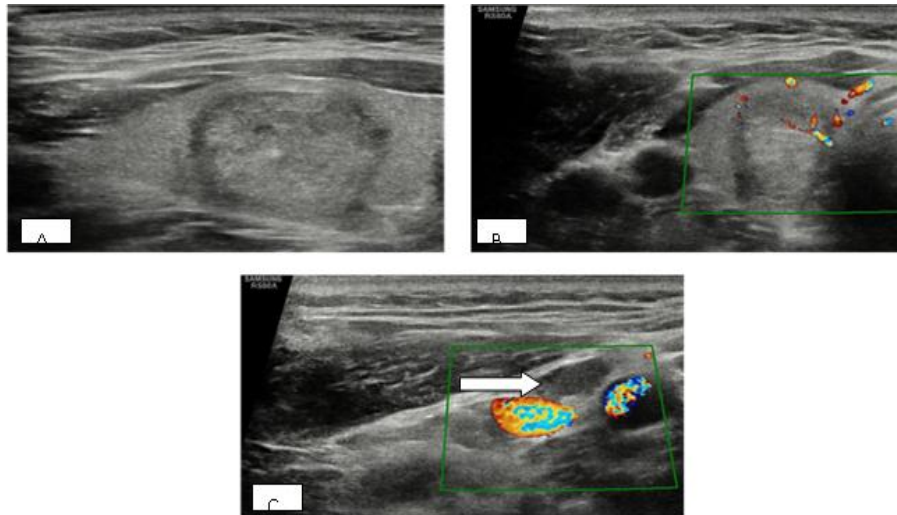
Image A, US image demonstrating a well defined (score 0), solid (score 2), hyperechoic/ isoechoic (score 1), taller than wide (score 3) nodule in right lobe of thyroid with areas of punctate echogenic foci (score 3) representing TIRADS V nodule (arrow) (Total score of 9). Image B, US image of the same patient demonstrating both peripheral and internal vascularity on colour doppler study. Image C, US image of the same patient demonstrating prominent ipsilateral cervical lymph node (arrow).
